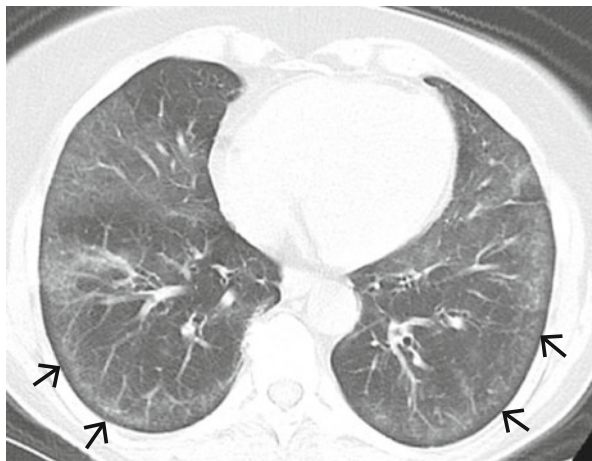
The radiographic appearance of non-specific interstitial pneumonia with characteristic rim of subpleural sparing, as indicated by the arrows
